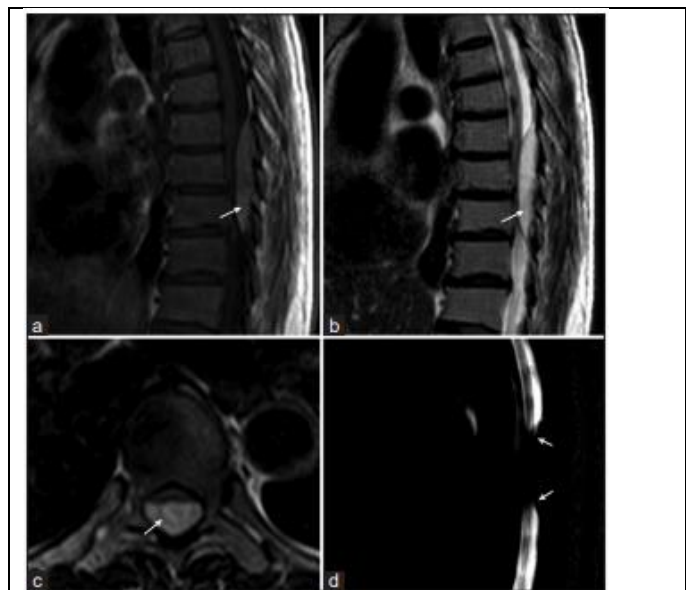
Magnetic resonance imaging reveals a focal mass at the dorsal extradural space at thoracic 7-10. (a and b) Coronal view with T1-weighted and T2-weighted images displaying the mass (white arrow). (c) Axial T2-weighted images reveal a dorsally positioned mass (white arrow). (d) Magnetic resonance myelography identifies the obstruction site (white arrow).
